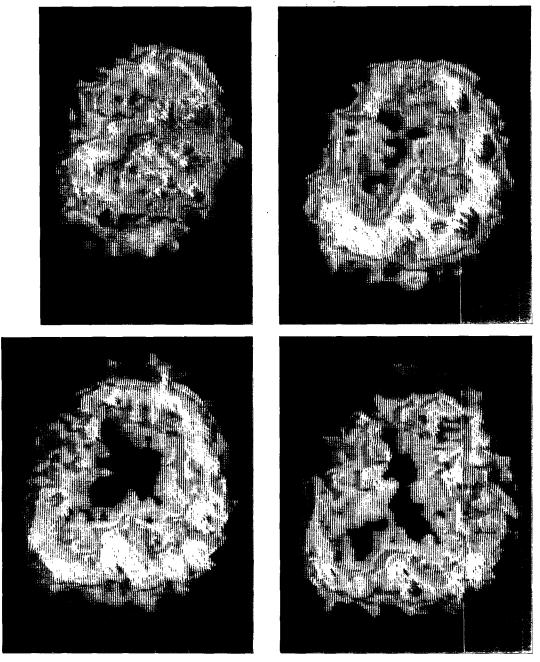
A case of infarct : larger ischemic zone on Tc-99m-HMPAO and small irreversible infarct on CT.
